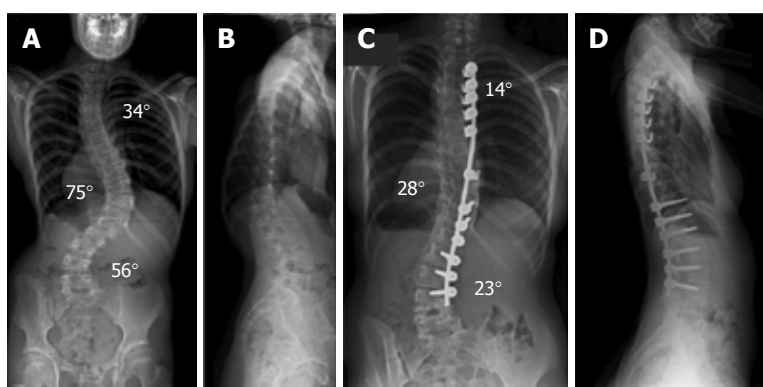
Patient with neuromuscular kyphoscoliosis. A: Preoperative postero-anterior spinal radiograph shows a triple thoracic and lumbar scoliosis; B: Preoperative lateral spinal radiograph shows a thoracolumbar rotatory kyphosis producing positive global sagittal balance of the spine; C: Postero-anterior spinal radiograph shows excellent scoliosis correction and a balanced spine in the coronal plane; D: Lateral spinal radiograph shows restoration of thoracic kyphosis and a normal sagittal balance of the spine.
